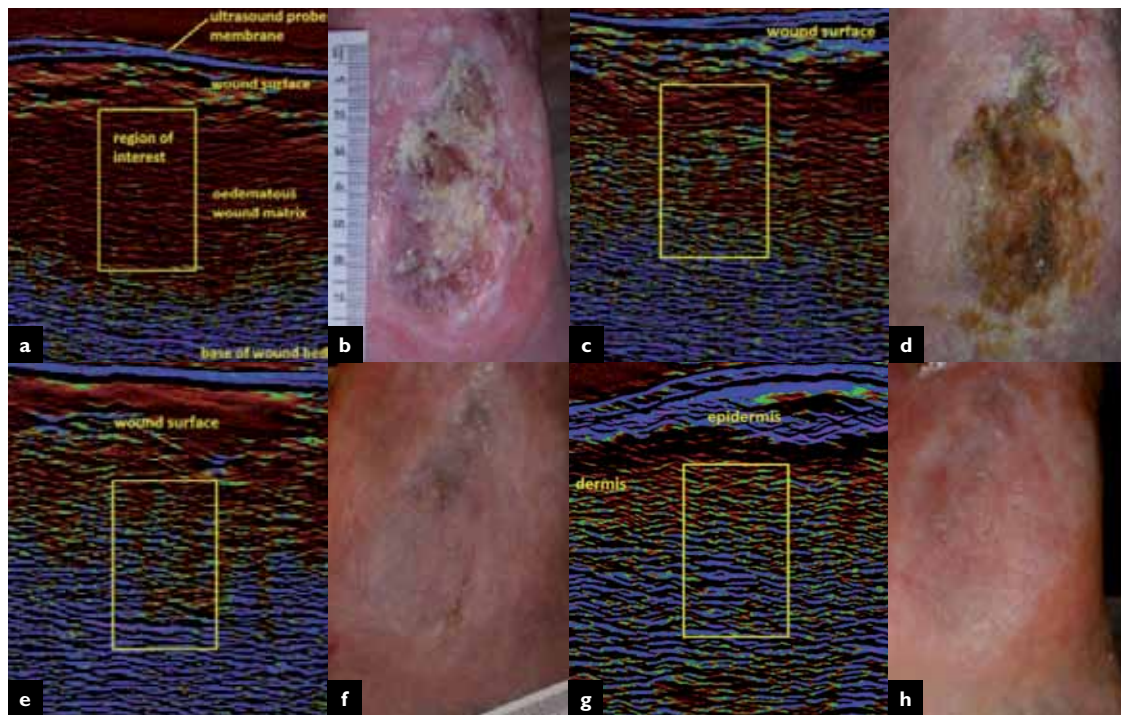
Sample ultrasound scans and wound photographs for time 0 (a)(b), day 10 (c)(d), day 20 (e)(f) and day 90 (g)(h)
